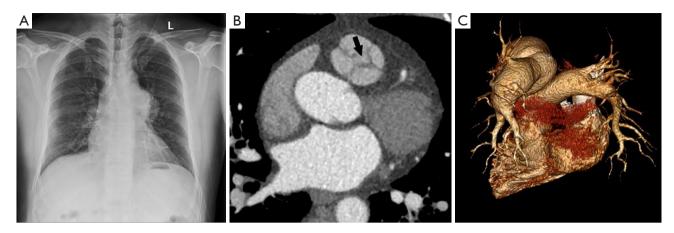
Quadricuspid pulmonary valve. (A) Chest X-ray shows enlarging of the pulmonary trunk and slender blood vessel shadow of the peripheral lung field. (B) Transpulmonary valve-level MPR reconstruction shows the quadricuspid pulmonary valve and incomplete central closure of the valve opening leading to pulmonary valve regurgitation (arrow). (C) VR reconstruction shows dilation of the main and left trunk of the pulmonary artery but no definite dilation of the distal branches. MPR, multiplanar reformation; VR, volume rendering.
